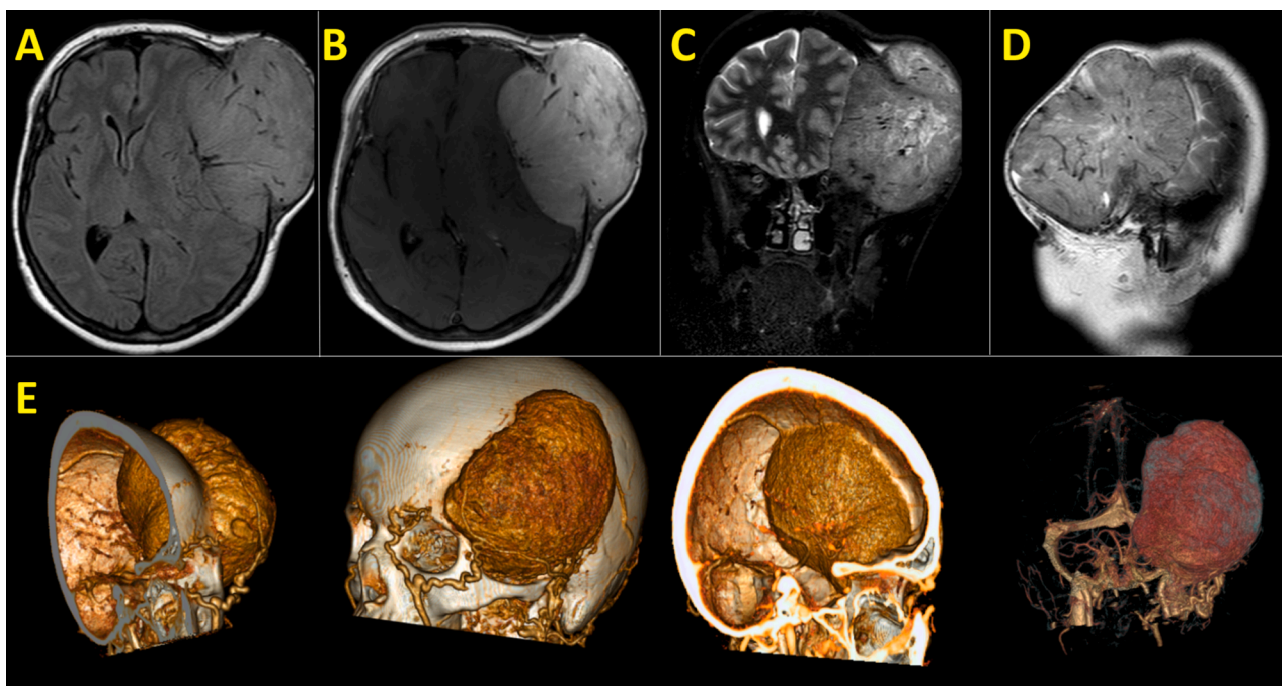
A — Preoperative axial T2-weighted/FLAIR imaging. B — Preoperative axial T2-weighted imaging with gadolinium. C — Preoperative coronal short tau inversion recovery imaging. D — Preoperative sagittal T2-weighted/TSE imaging. E — Preoperative three-dimensional CTA reconstruction. A giant ($105 \times 102 \times 75$ mm) hypervascular extracerebral mass lesion with extra-intracranial growth, cerebral compression, and 10-mm right-sided axial shift.
